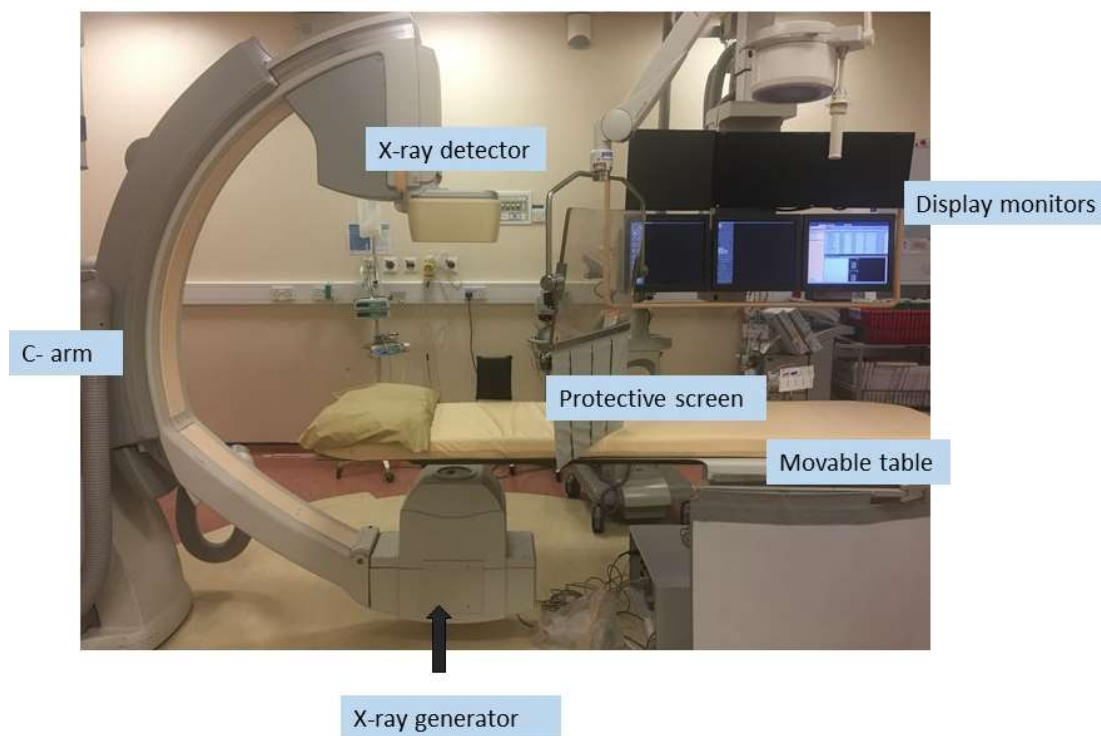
Catheter lab 6 at Leeds General Infirmary where majority of the research work was carried out. The X-ray generator and detector are mounted on a C shaped arm (C-arm) which moves around the patient lying on a movable table. Lead protection screens are used to protect the operator from radiation exposure. The X-ray images are displayed on ceiling mounted display monitors.
